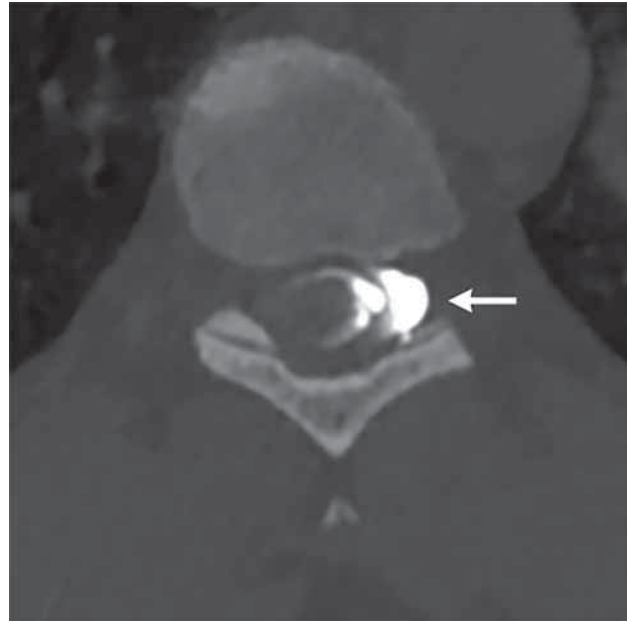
Type 2 CSF leak (ruptured meningeal diverticulum): left decubitus CT myelogram in the axial plane shows contrast leaking from the left T9–T10 meningeal diverticulum into the neural foramen (arrow).
